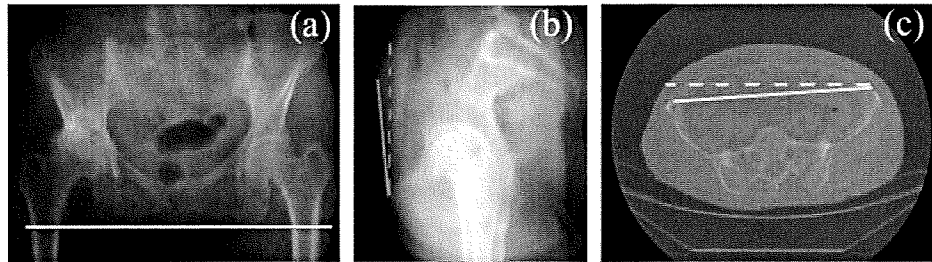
Pelvic coordinate system. (a) The coronal plane corresponded with the plane of the CT table. The line joining the the ischial tuberosities is defined as the horizontal axis (white line). To match between preoperative and postoperative pelvic orientations, the pelvic tilt (b) is the angle between the line of the anatomical plane of the pelvis (solid grey line), through the bilateral superior anterior iliac spines and the superior margin of the pubic symphysis and the vertical line (dotted grey line) on the sagittal view is recorded. The angle (c) between the line (solid white line) joining the bilateral superior iliac spines and the horizontal line (dotted white line) is also recorded
